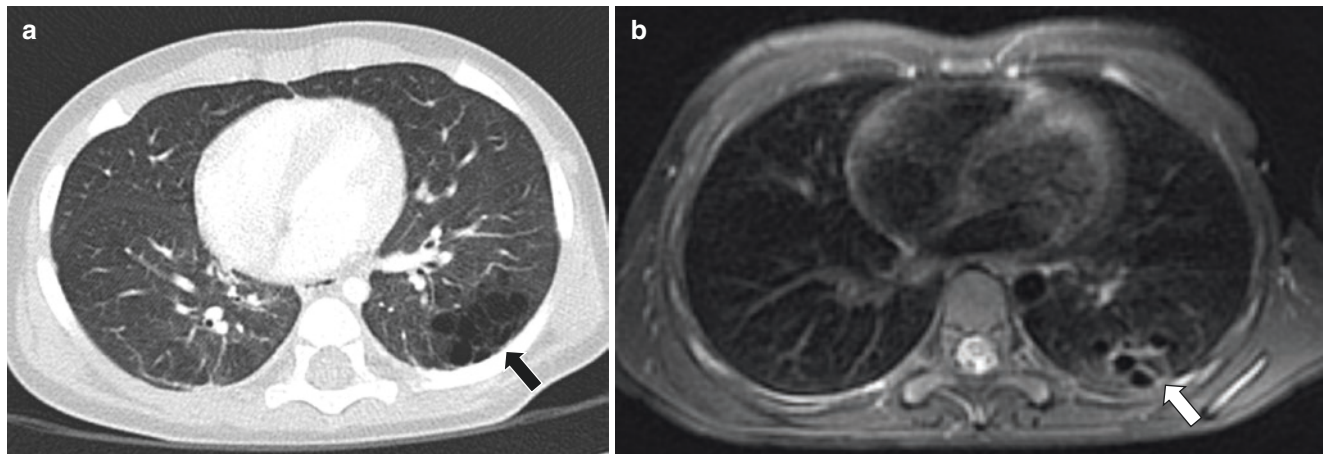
Congenital pulmonary airway malformation (CPAM) type 2 in a boy at 7 months old and 9 years old. (a) Axial enhanced lung window setting CT image at 7 months of age shows multiple cysts
